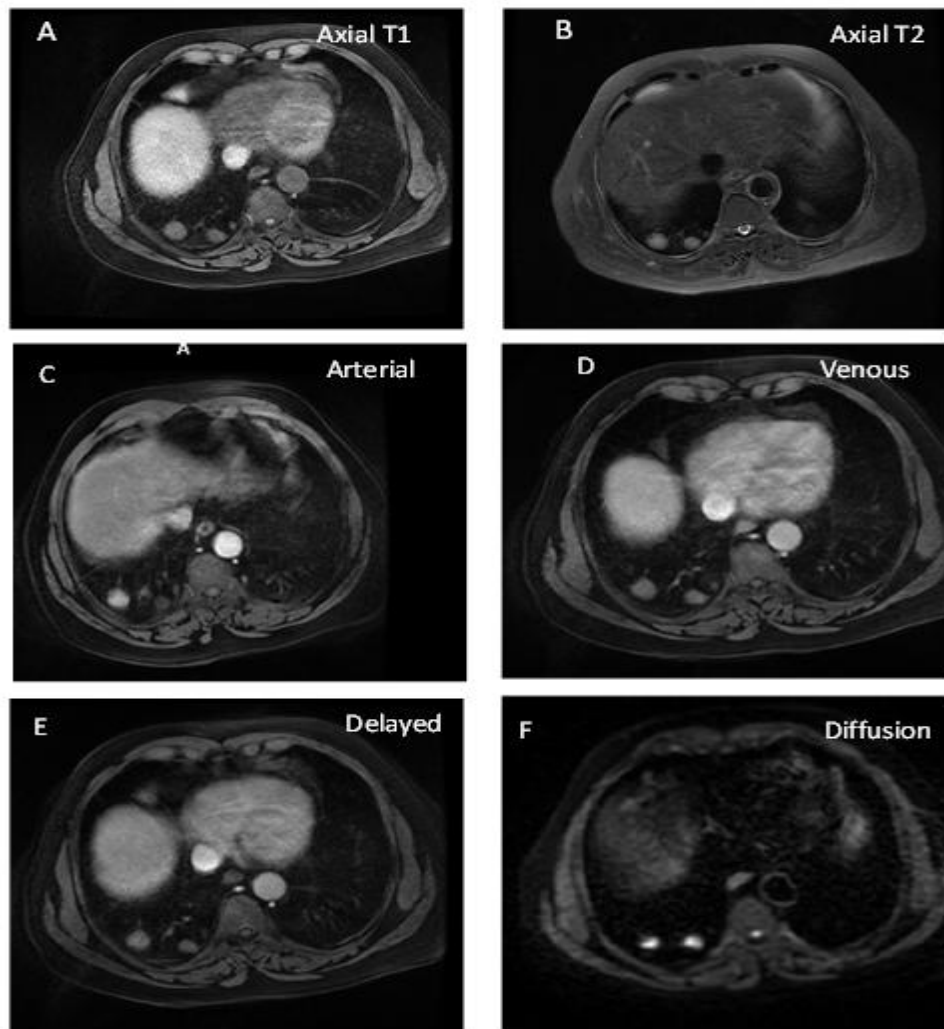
Case number 2. Two pulmonary nodules seen at right lower lung lobe, the largest measures about (2.2x1.8 cm) and the other measures (1.5x1 cm), the nodules seen displacing isointense signal at T1 (A)&T2 (B). While after dynamic post contrast phases that lasts for 4 minutes the nodules showing arterial enhancement (C) and washout at subsequent phases (D&E). ADC value is 1.2×10^{-3} mm²/s with restricted diffusion (F) (nodules are bright). The time-enhancement curve is of type B (G). CT examination revealed two pulmonary nodules seen at right lower lung lobe, largest measures about 2.3x2 cm, after 3 months the size increased to 2.6x2.4 cm then after another 3 months the size became 3x2.5 cm and other tiny nodules appeared at the other side
